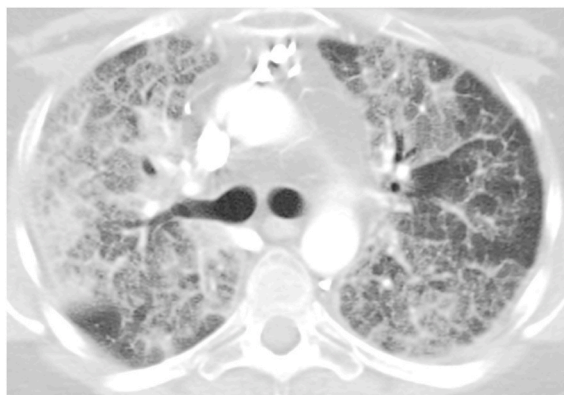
Computed tomography (CT) scan of chest at the time of diagnosis. Imaging was performed on a GE medical systems scanner, and axial images were reformatted at 6mm slice thickness during administration of intravenous contrast (dFOV = 36 cm). CT scan shows dense bilateral thickened inter and intralobular septa, ground-glass opacification, and consolidation involving the right greater than the left lung. Other findings include a nonocclusive small right lower lobe posterior basal segment pulmonary embolism.
